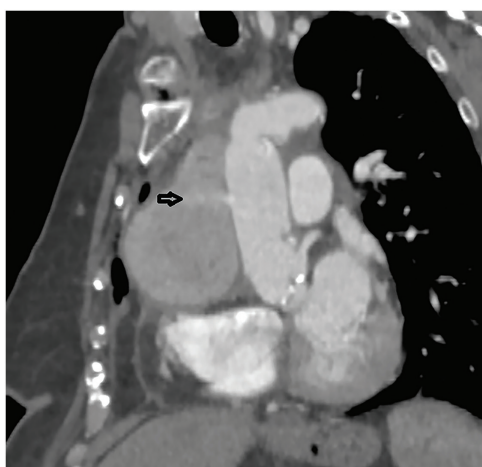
A CTA revealed a large pseudoaneurysm with a clear jet of contrast – marked with arrow.
